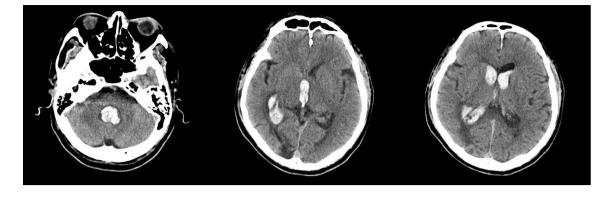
Computed tomography of the brain shows intraventricular hemorrhage in the third, fourth, and lateral ventricles
